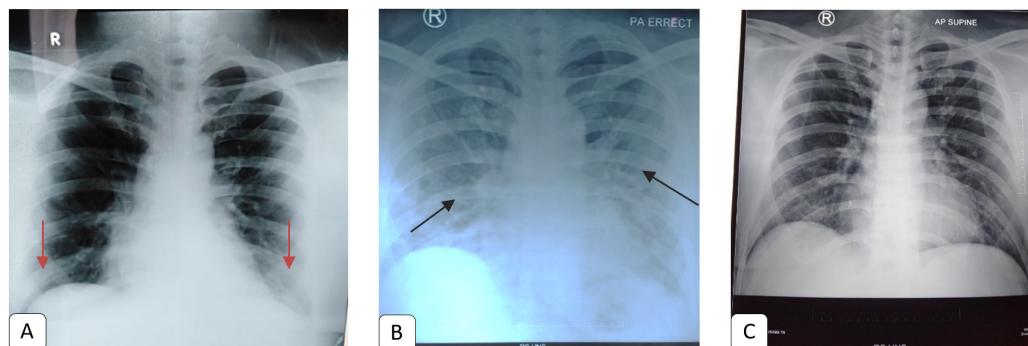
Radiological data of the stages of the illness. Figure A, September, 27th 2020, the patient experienced fever and nausea and diagnosed with typhoid fever, X-ray result minimal consolidation opacities bilateral in lower zone (red arrows). Figure B, October 1st 2020, the patient reported shortness of breath, and the blood gas analysis showed respiratory failure, a visible increase in broncho vascular streak and infiltrates bilateral (black arrows). Figure C, October, 9th 2020, the patient received TPE twice, the chest X-ray result went back to normal.
